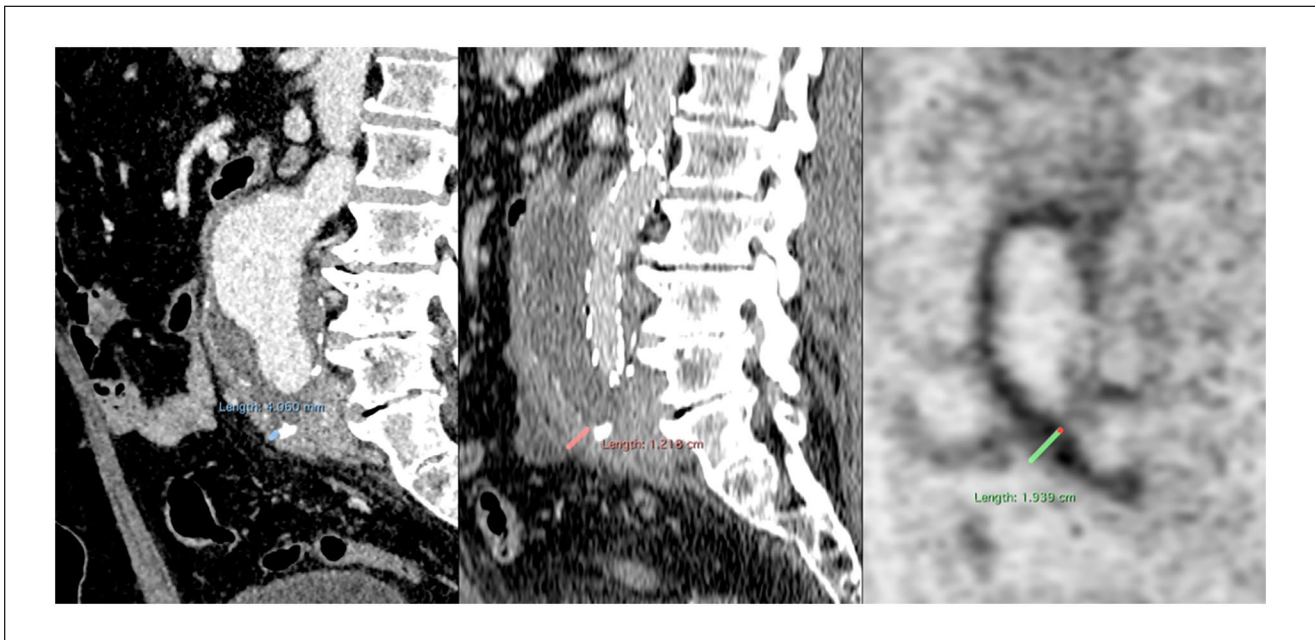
Preoperative coronal CT scan image showing absence of periaortitis (A), periaortitis after EVAR at CT scan (B), and 18F-FDG PET/CT (C).
